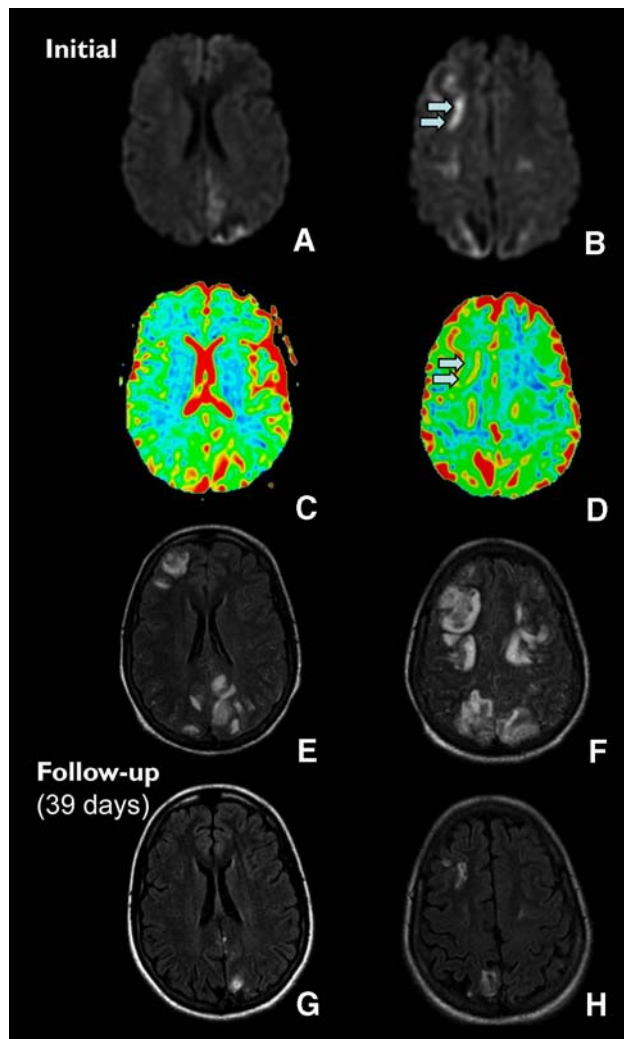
Posterior encephalopathy related to cyclosporine treatment. Brain MRI in diffusion-weighted (a, b) ADC map (c, d) and FLAIR (e, f) sequences from 17-year-old patient 1, who presented seizures 6 days after heart transplantation. Multiple areas of increased signal predominating on the posterior and central region on FLAIR sequence are highly suggestive of the diagnosis of posterior reversible encephalopathy syndrome (PRES). Most lesions are isointense on diffusion sequence, present an increased ADC and correspond to vasogenic edema. However, some areas of hyperintense signal are present, have a normal ADC (e.g., on the right frontal gyrus, arrow) and correspond to a mixture of cytotoxic and vasogenic edema. The control examination performed 39 days after modification of the immunosuppressive regime (FLAIR sequence, g, h) shows the complete regression of the vasogenic lesions and the presence of persistent parenchymal destruction in the areas where cytotoxic edema was present
